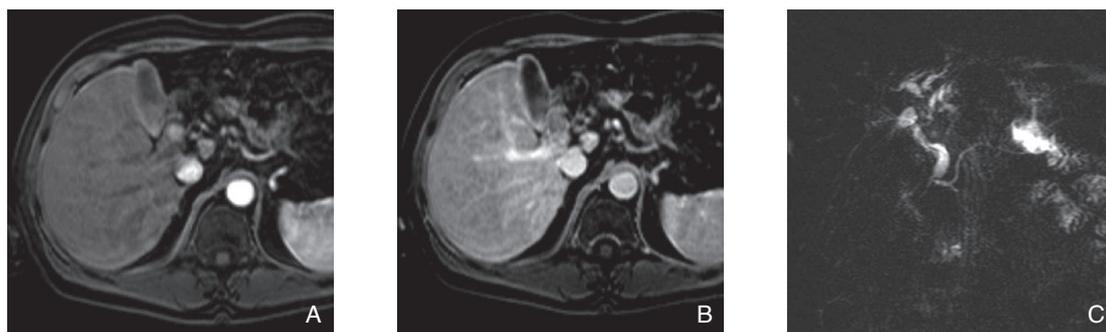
A 为肝动脉期的平扫增强 MRI 及门静脉期；B 为小的管腔内多血管肿块，在门静脉期减弱；C 为冠状位的 MRCP 示在左右肝管回合部的肿块引起肝内胆管扩张
